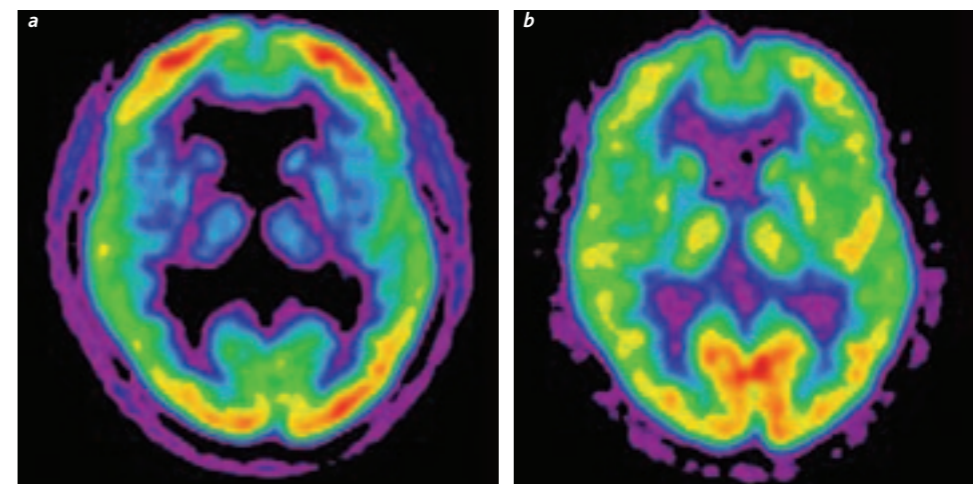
Axial FDG brain image: (a) without attenuation correction showing net attenuation of the important central cerebral structures (basal ganglia and thalamus) and giving the appearance of the patient having a hydrocephalus; and (b) after attenuation correction. These structures demonstrate FDG uptake comparable to the cortex.
